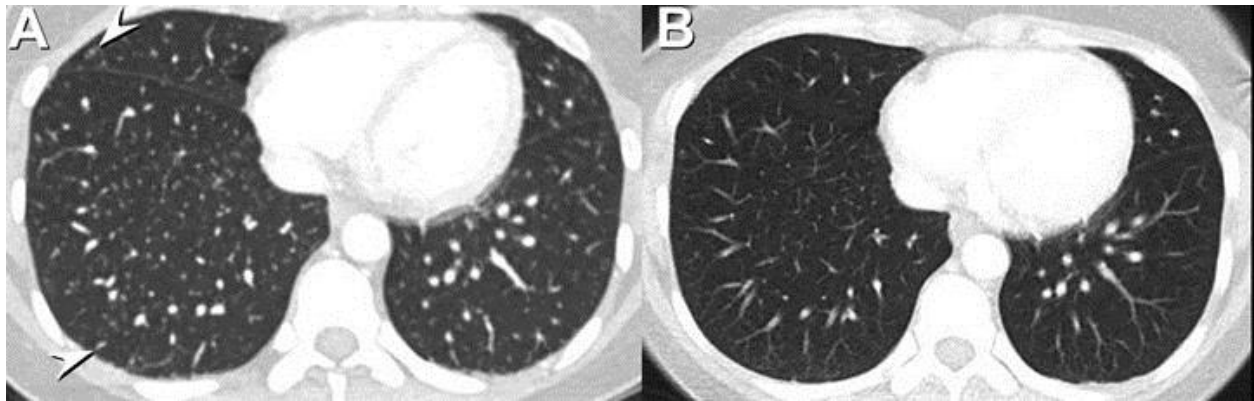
Comparison of lung bases from CT abdomen and pelvis at presentation (A) and 1 month earlier while the patient was hospitalized at an outside institution. Note that numerous, small, circumscribed nodules at presentation (arrowheads, A) have developed over the previous month (B).
